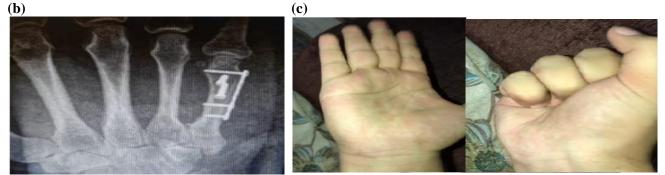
(a) 2 weeks postoperative x-rays showing fracture of 5^{th} metacarpal, (b) 3months postoperative x-rays showing fracture of 5^{th} metacarpal with complete union, (c) 3months follow up showing excellent outcomes.
